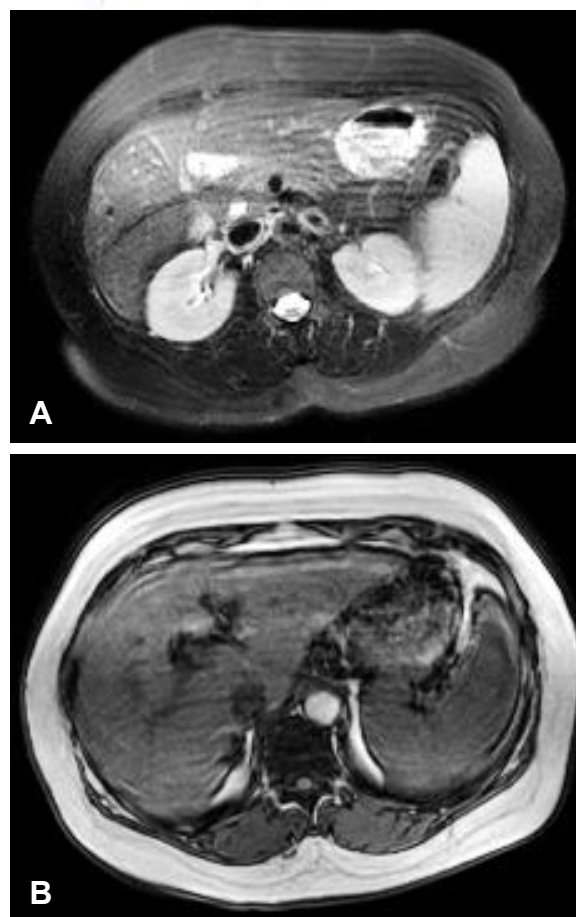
53-year-old female with a limited ability to breath-hold during liver imaging. (A) Axial T2-weighted fat suppression. (B) Axial T1-weighted spoiled gradient echo. Total breath-hold time was 0:22 and 0:26 seconds, respectively. The line-like artifacts throughout the images are the result of excessive respiratory motion.
